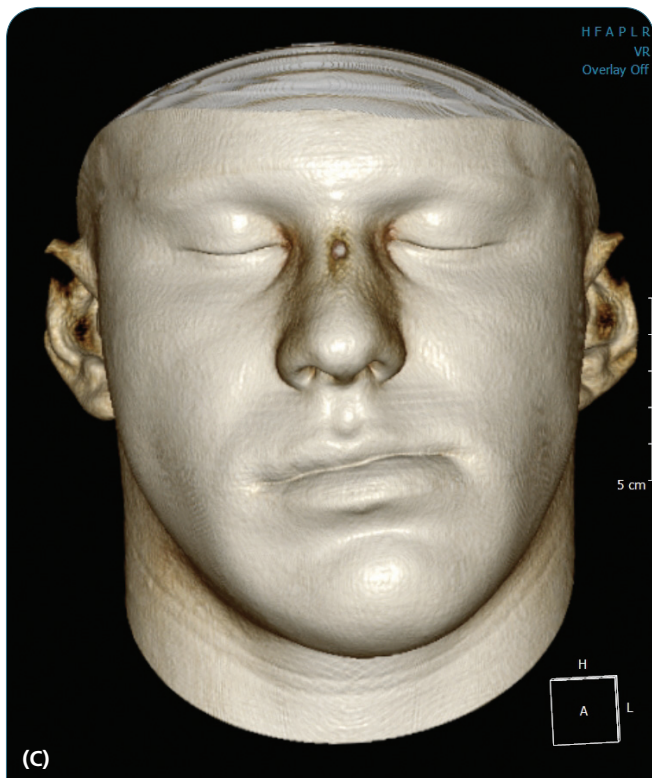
(continued) (C) Photograph of a frontal view of the patient. (D) Front view showing the realignment of the maxilla and the mandible. (E) X-ray of patient after treatment. (F) Photograph of frontal view of patient after surgery. (Courtesy of Imaging Sciences Inc.)
